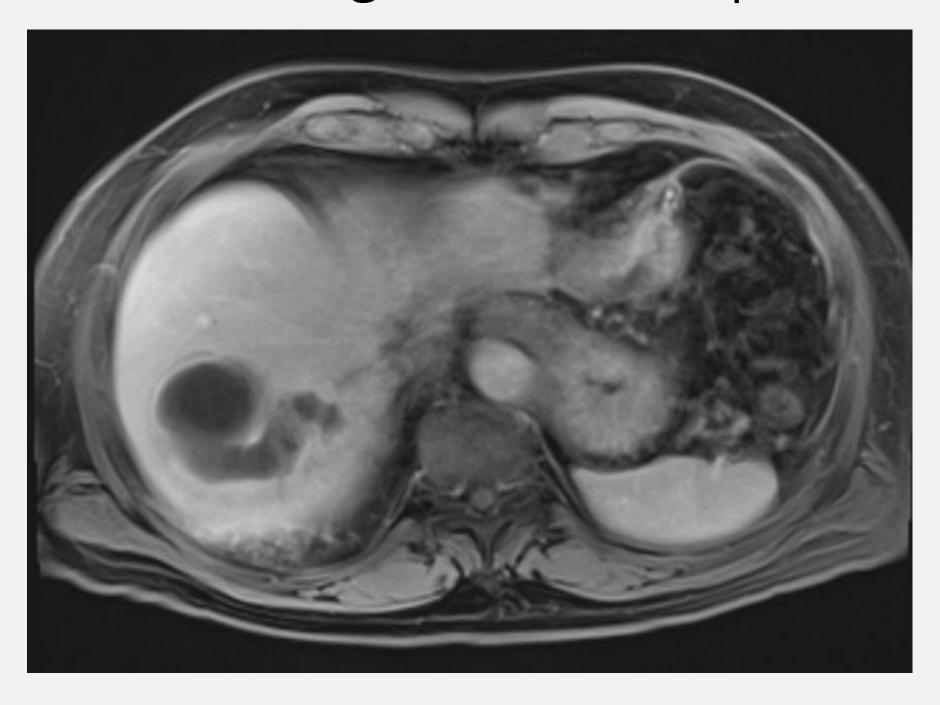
initial inpatient MRI AP with contrast
